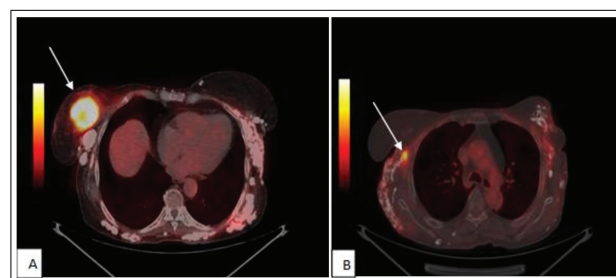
Axial fused images of 18F-FDG PET/CT scan revealing a voluminous hypermetabolic pathological mass in the right breast (Panel A) and suspected hypermetabolic pathological right axillary lymphadenopathy (Panel B).
